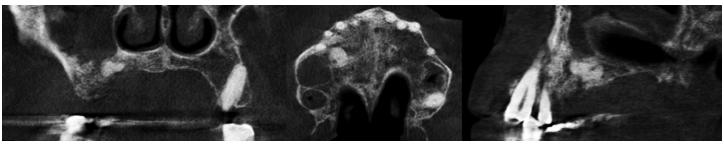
CBCT images showing a prostate cancer metastasis in the maxilla. The lesion demonstrates a hyperdense internal structure with ill-defined borders. Destruction of the floor of the maxillary sinus is evident and closely associated with the lesion.
